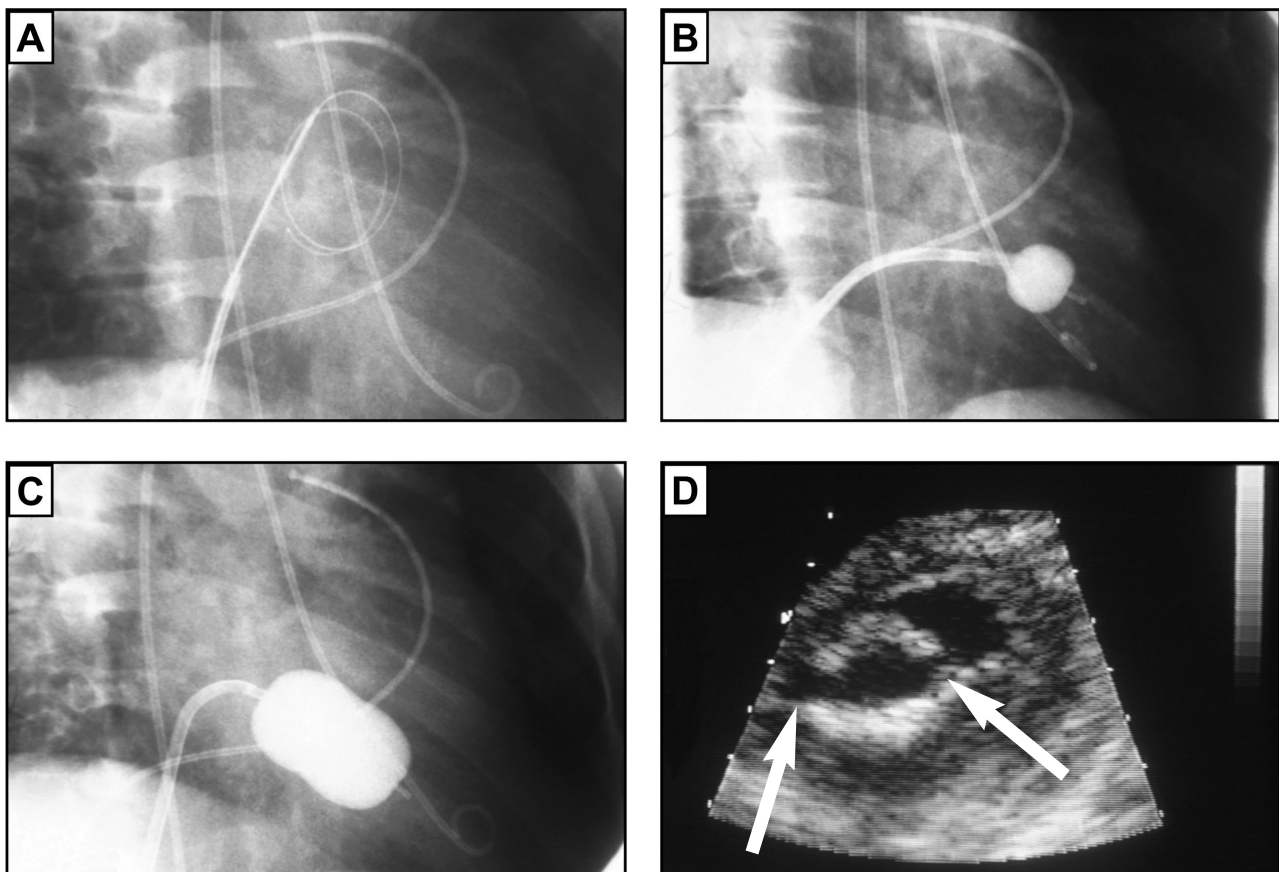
Right anterior oblique angiographic views showing (A) the stretched Inoue balloon catheter, which has been advanced transseptally over the Inoue guide wire into the left atrium, (B) across the mitral valve with partial inflation of the distal half of the balloon below the valve, and (C) fully inflated across the mitral valve. A Swan-Ganz catheter and pigtail catheter have been placed in the pulmonary artery and left ventricle respectively. (D) Short-axis echocardiographic view showing separation of both commissures (arrowed) of the thickened mitral valve.
